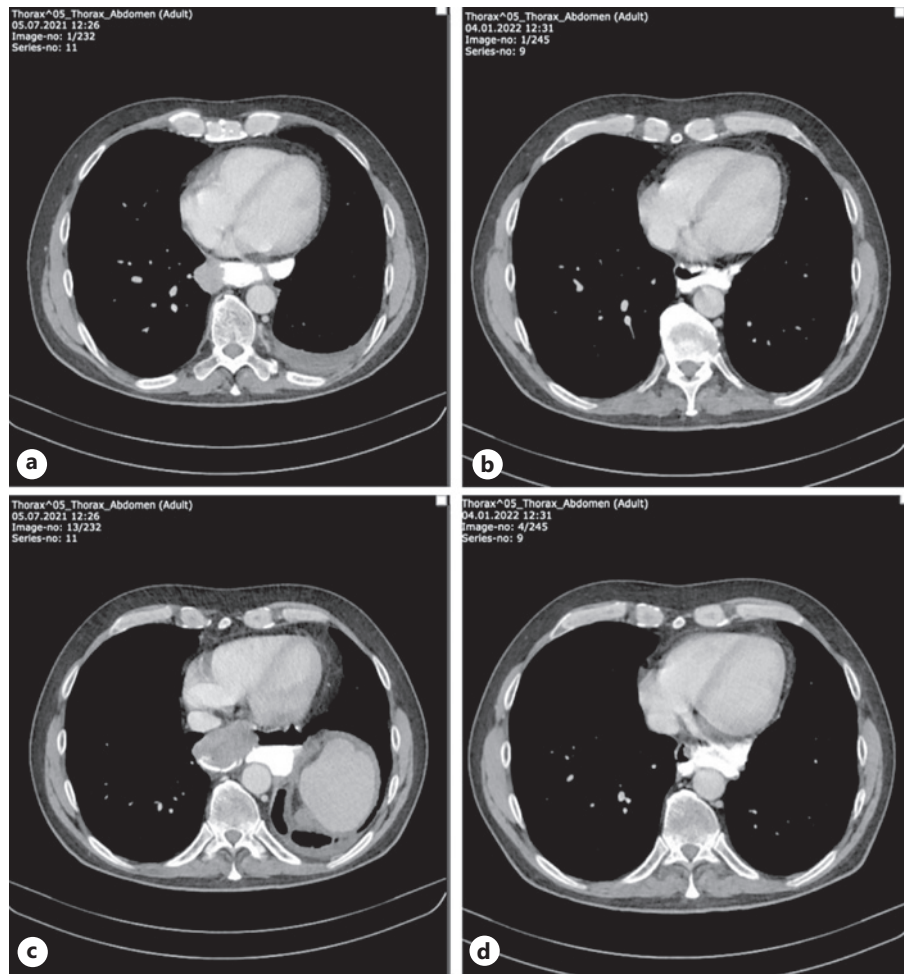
CT imaging of the patient before and after treatment with Pembrolizumab and Olaparib. a, c July 2021: the patient shows a tumor burden in the posterior mediastinum with enlarged paravertebral lymph nodes. b, d January 2022: notable decrease of the tumor mass within the mediastinum but also the paravertebral lymph nodes.
